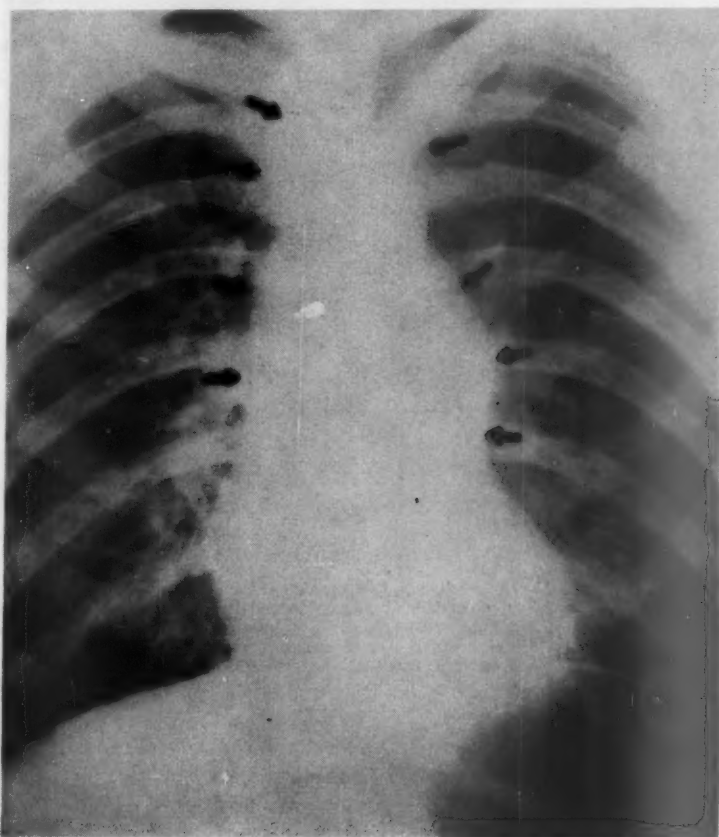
The posterior-anterior roentgenogram of the chest of a 21 year old male whose only complaint was a mild dyspnea on exertion. A large, dense mass occupies the superior mediastinum, which blends with the cardiovascular silhouette (outlined by arrows). This is a good example of how some mediastinal masses can be undetected on a routine posterior-anterior chest roentgenogram. This abnormality was not interpreted by readers of previous chest roentgenograms.
